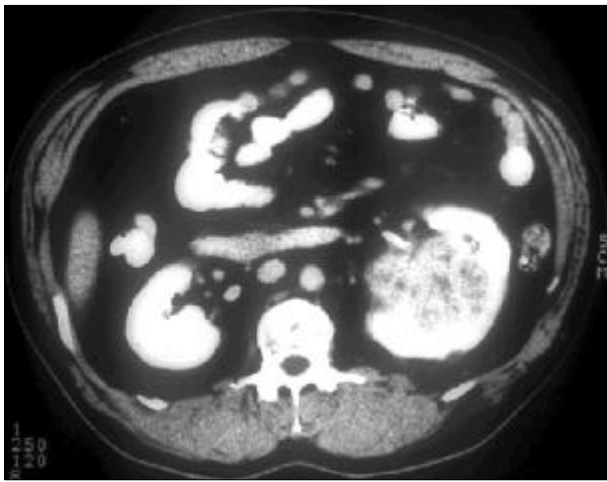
Abdominal CT showing a solid mass occupying the entire left Kidney.
